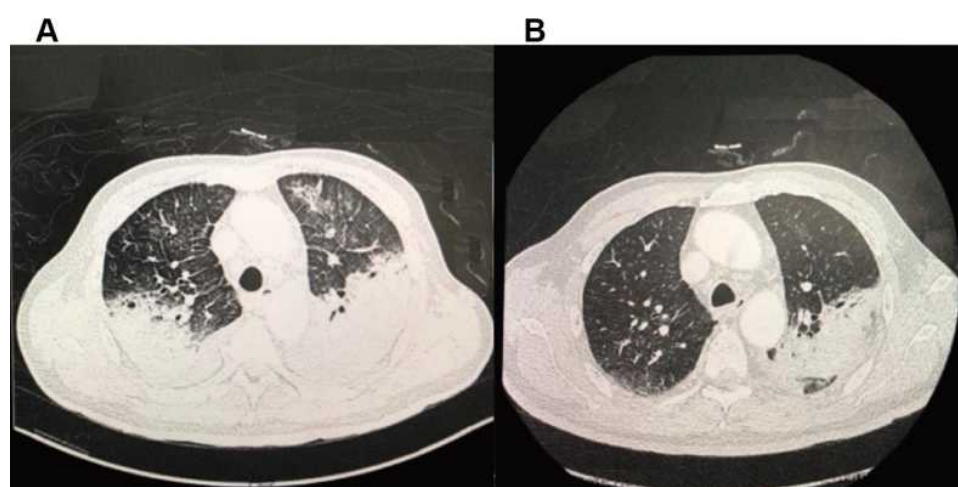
Chest computed tomography (CT) scans of a 66-year-old man with *C. psittaci* pneumonia. Lungs were exuding consolidation foci, bilateral pectoral effusions, consolidation on the 8th day of hospitalization (A). After treatment, on the 18th day of hospitalization (B), the image of four patients improved, and the patients' lung exudation, consolidation, and bilateral pleural effusion were less than before.
